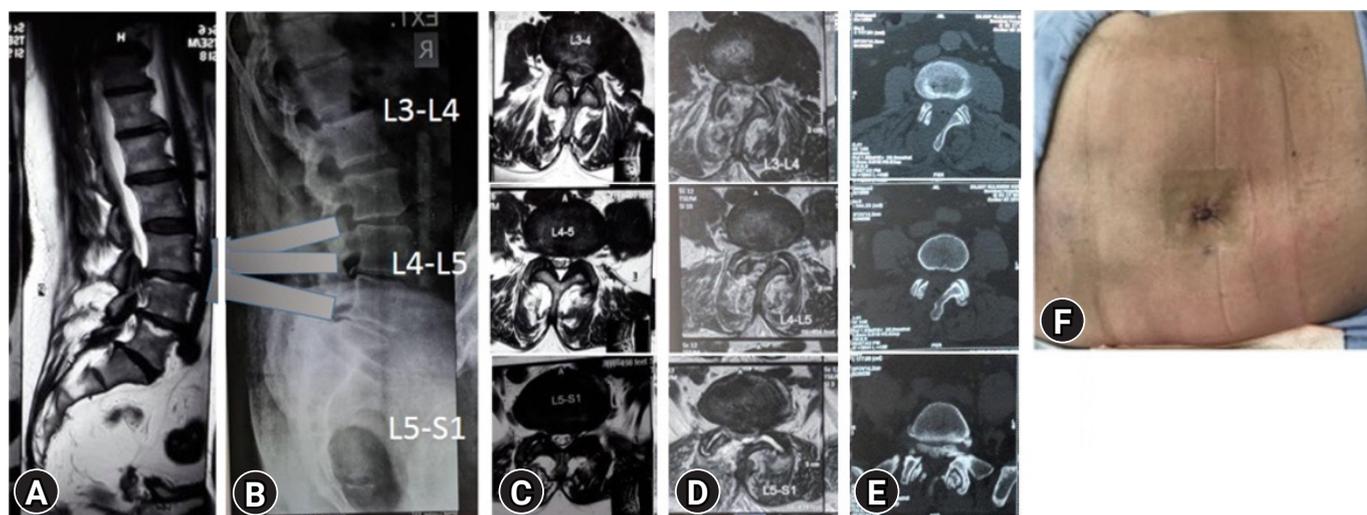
A 68-year-old male (case 41) – preoperative MRI sagittal and axial (A, C) and lateral radiograph showing tube trajectories (B). 6 months post-operative axial MRI and CT scan (D, E) showing adequate decompression. Post-operative single surgical scar (F).
